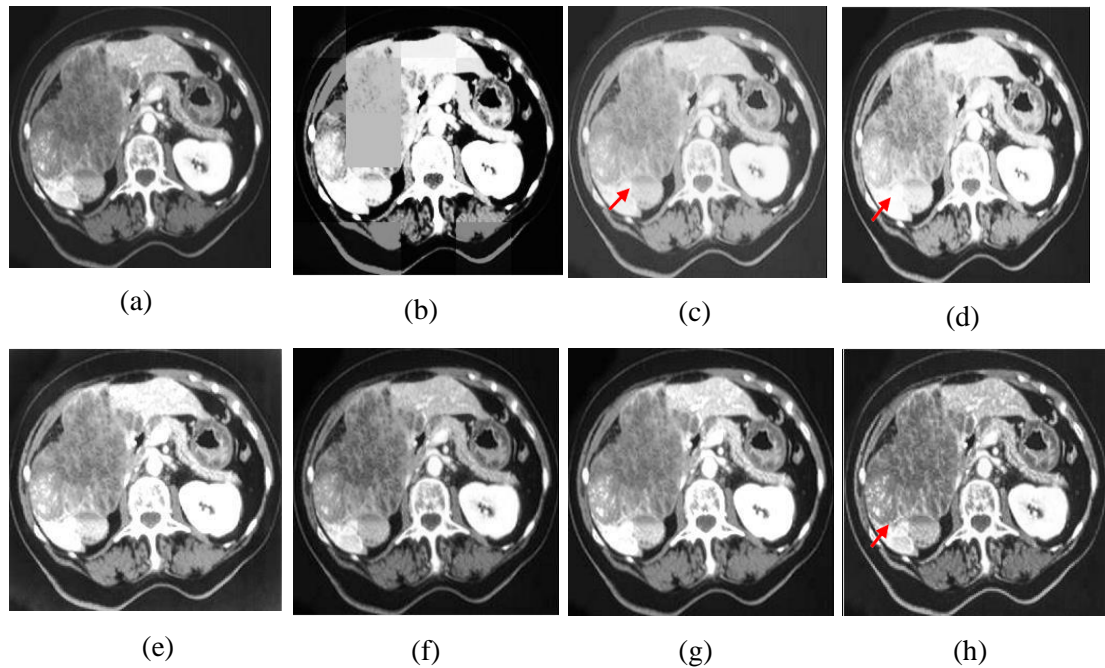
3.4 Input "CT-1" image and it's associated enhanced images (a) Input image, (b) S-curve, (c) AGC-DWT, (d) AGC- WHD, (e) GAGC-DWT, (f) EBCHE, (g) TCHE-DWT, (h) Proposed technique
